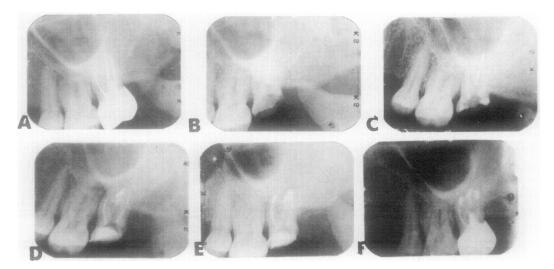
Case 6. Maxillary right second molar of 44-year-old white woman. A, Preoperative radiograph showing previous root canal treatment performed with silver cone technique. Post is present in palatal root. Treatment has been performed 3 years previously by general dentist. Patient now has pain and percussion sensitivity. B, Conventional retreatment is attempted. Radiograph shows crown, post, and mesiobuccal and distobuccal silver cones removed. Silver cone is lodged in palatal canal. C, Radiograph demonstrating mesiobuccal and distobuccal canals filled with gutta-percha. Silver cone is present in palatal canal. D, Immediate postoperative surgical radiograph. Surgical flap is reflected on palatal aspect. Apical portion of palatal root is removed to loosen silver cone. Silver cone is pushed up and out of canal through occlusal opening. Canal is reinstrumented and is filled with gutta-percha. Post preparation is made in palatal root; retrograde amalgam is placed. E, Immediate postoperative surgical radiograph. Surgical flap is reflected on buccal aspect. Because of apical blockage from silver cone byproducts, mesiobuccal and distobuccal roots are sealed with retrograde amalgams. F, Recall radiograph approximately 3 years later demonstrating restored, asymptomatic tooth with apical bony regeneration.
